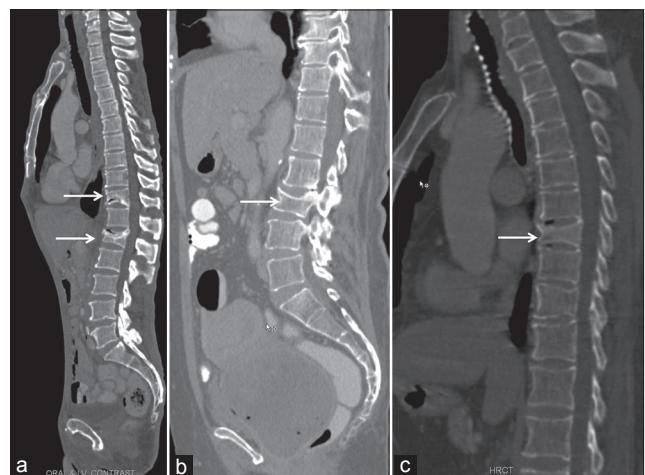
MDCT sagittal reformatted images in three different patients undergoing abdominal CT scans for other indications clearly show incidentally detected multiple vertebral fractures (arrows)
